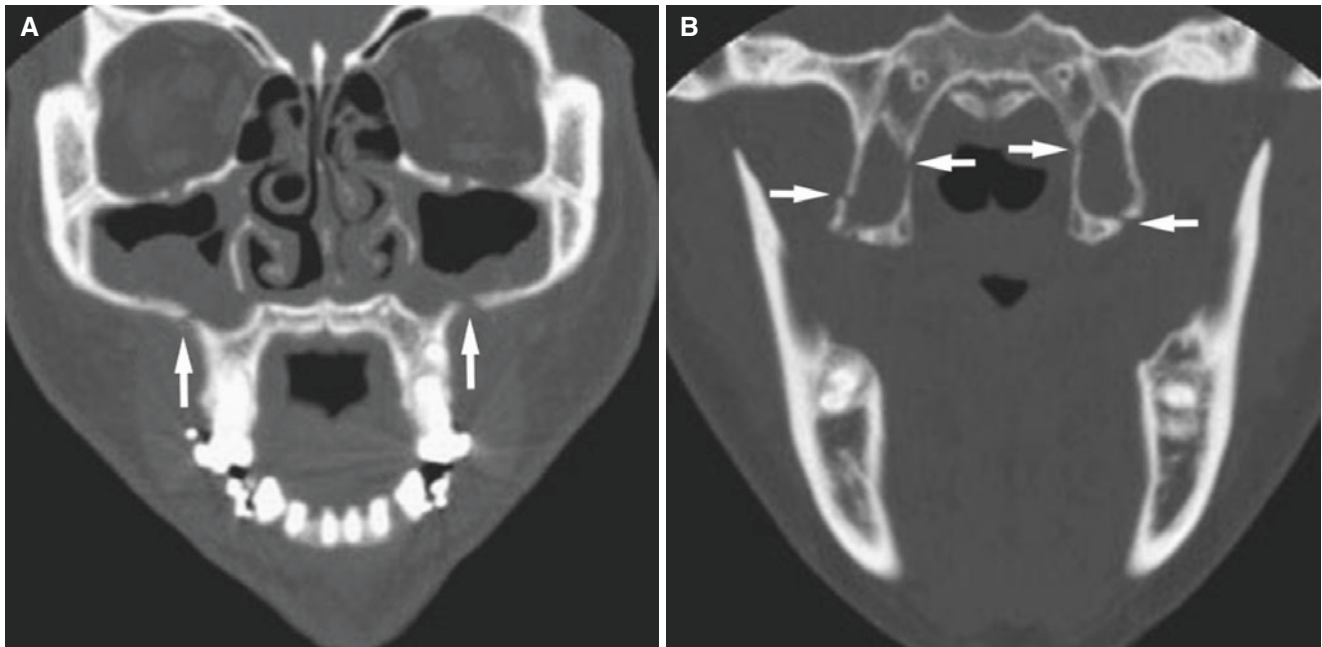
LeFort 1 osteotomies; 48-year-old female with pain and facial swelling after maxillary surgery. (A) Coronal CT image shows osteotomy defects in anterolateral maxillary walls (*arrows*) and through
